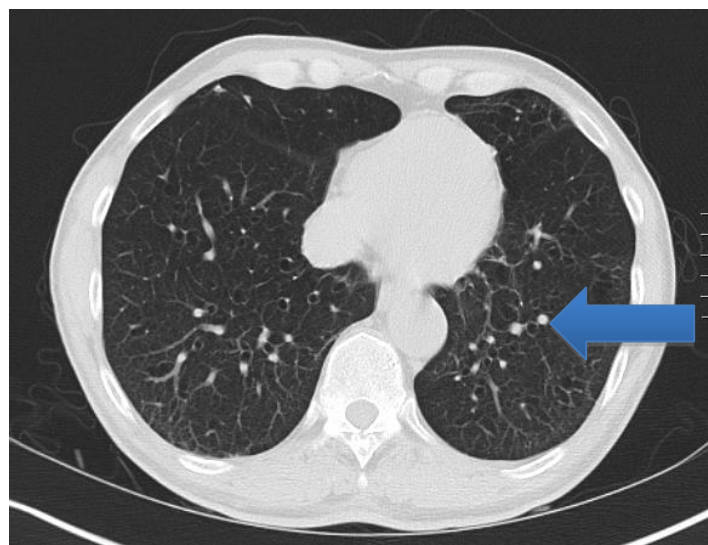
Appearances of bronchiectasis on CT. This is a scan of the thorax at the level of the heart. It represents a cross-sectional slice of tissue viewed as if you are looking towards the patient's head. Thickened and enlarged bronchioles can be seen. An example of such a bronchiole is highlighted.
